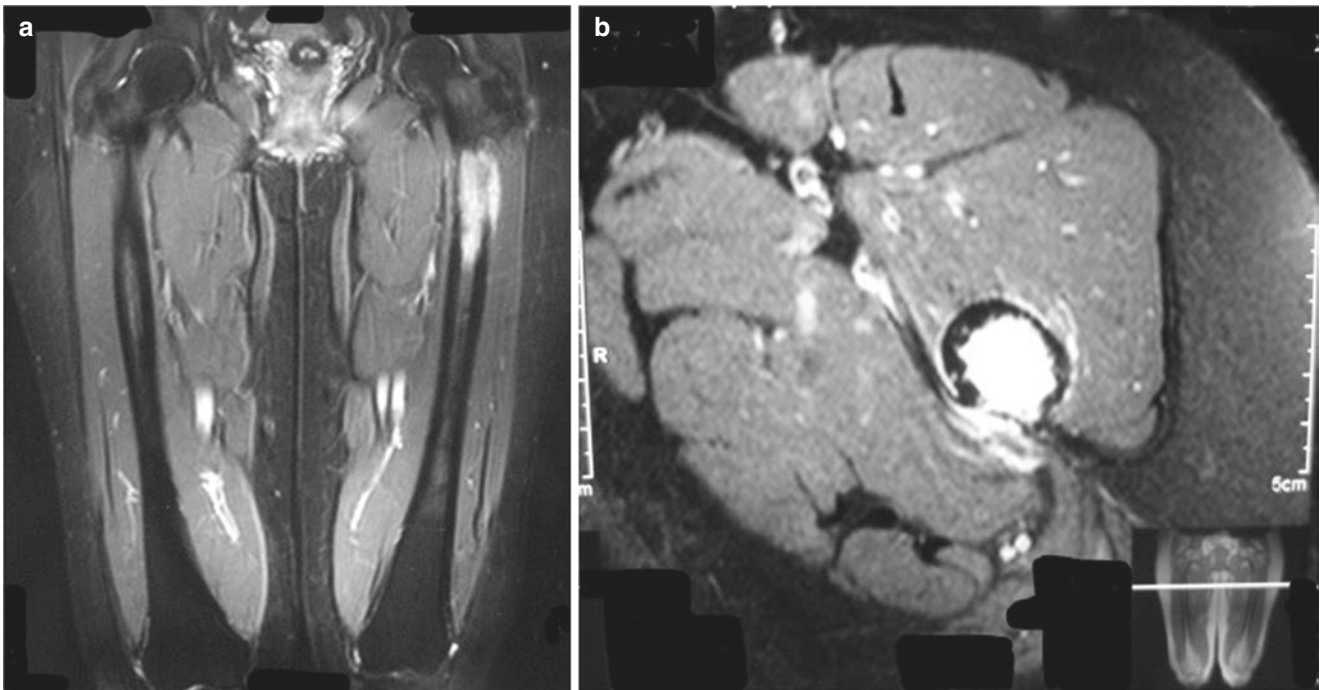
MRI T1-weighted/GD/FS of the femur demonstrating a hyper-intense tumor, cortical destruction with minor soft tissue tumor extension at the left proximal femur in coronal view (a) and axial view (b)
